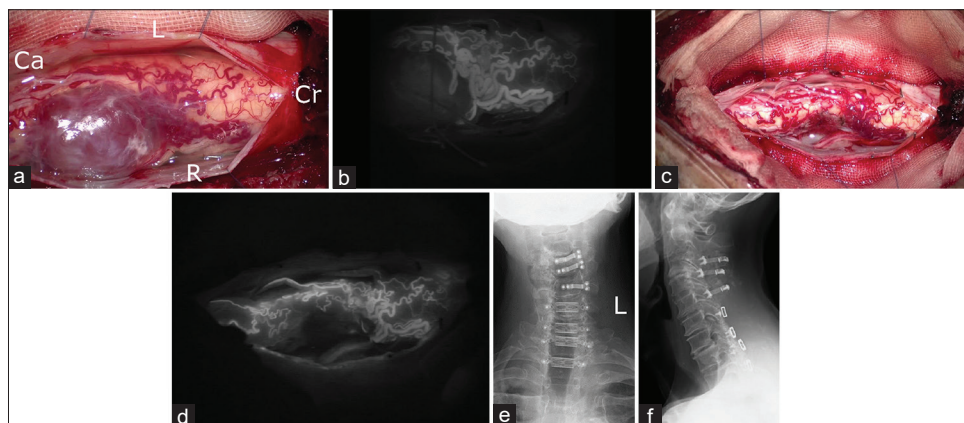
Intraoperative imaging (L: Left). (a) After opening the dura, the intradural extramedullary tumor was detected. The tumor is compressing the spinal cord (Ca: Caudal; Cr: Cranial; R: Right). (b) The tumor feeder and drainer are visualized with indocyanine green. (c) The tumor is removed. (d) Total removal of the tumor is confirmed with indocyanine green. (e) Posterior-anterior projection of X-ray; (f) Lateral projection of X-ray. Laminoplasty from C3 to T2 was also performed
